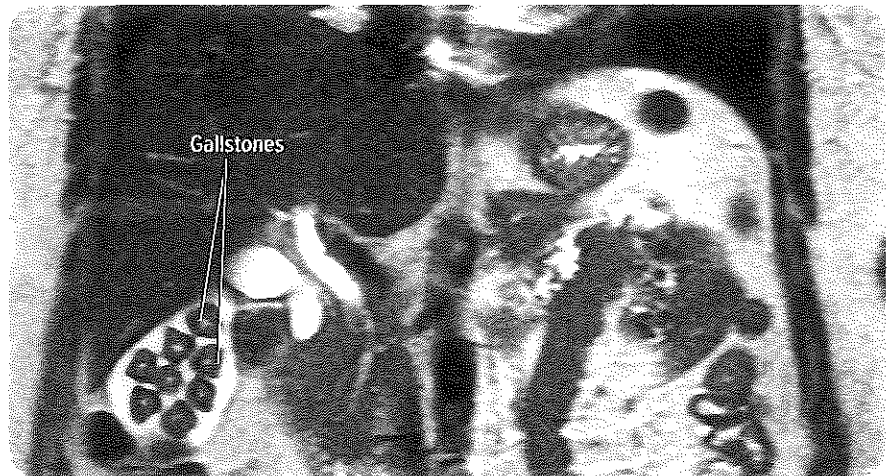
Gallstones can obstruct the flow of bile from the gallbladder. Note the gallstones on this MRI film of a gallbladder.
